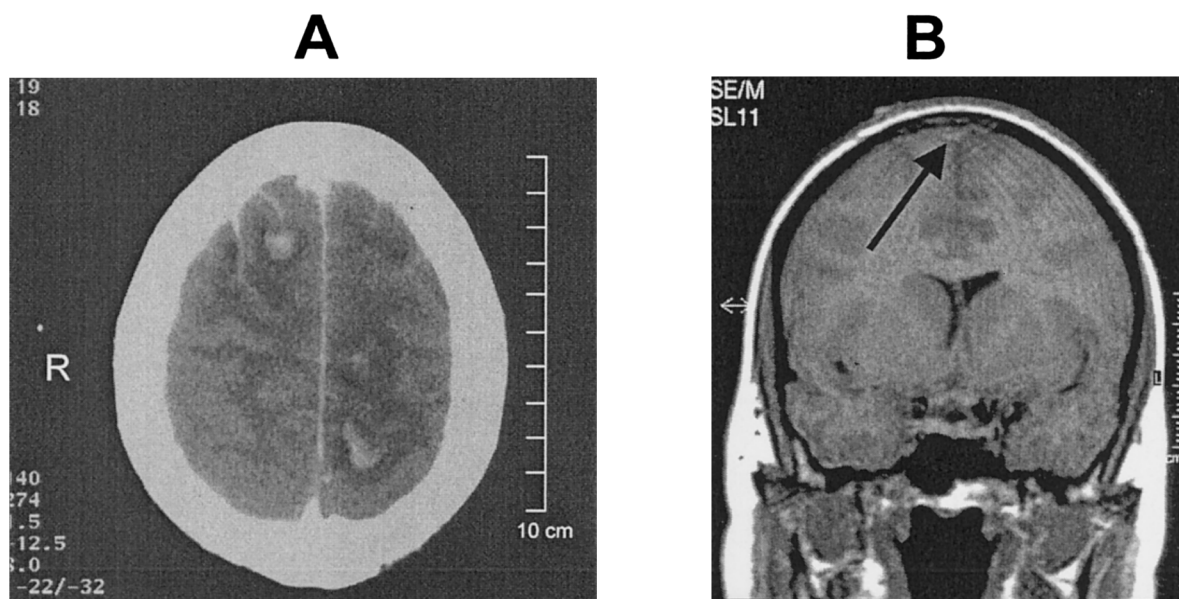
(A) CT scan of the brain with multiple haemorrhagic infarcts. (B) T1 weighted coronal section of a MRI scan of the head with a hyperintense lesion in the superior sagittal sinus (arrow).
